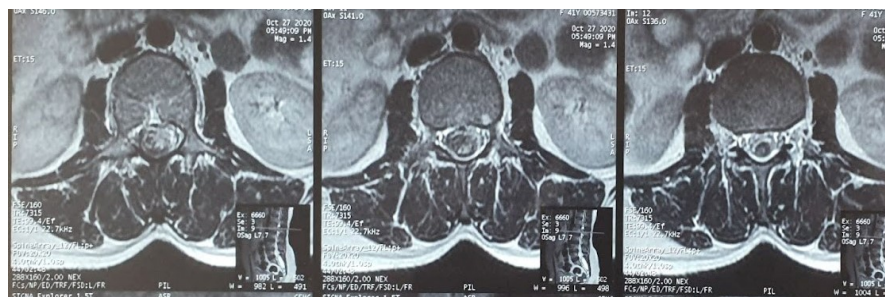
MRI axial sections. T2-weighted sequences showing the intramedullary tumor in the conus medullaris.
